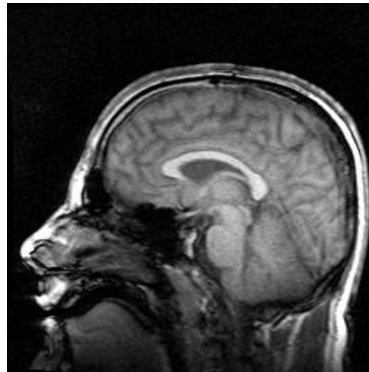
MRI Brain Scan from Side View<sup>17</sup>
